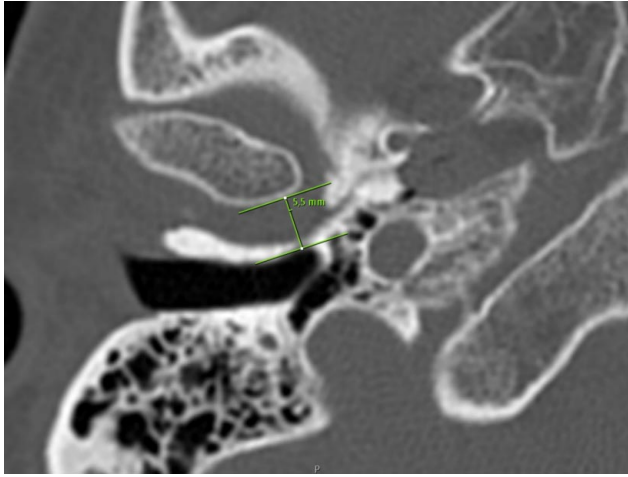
Temporal CT image of a 58-year-old woman (Right Total NTT).
